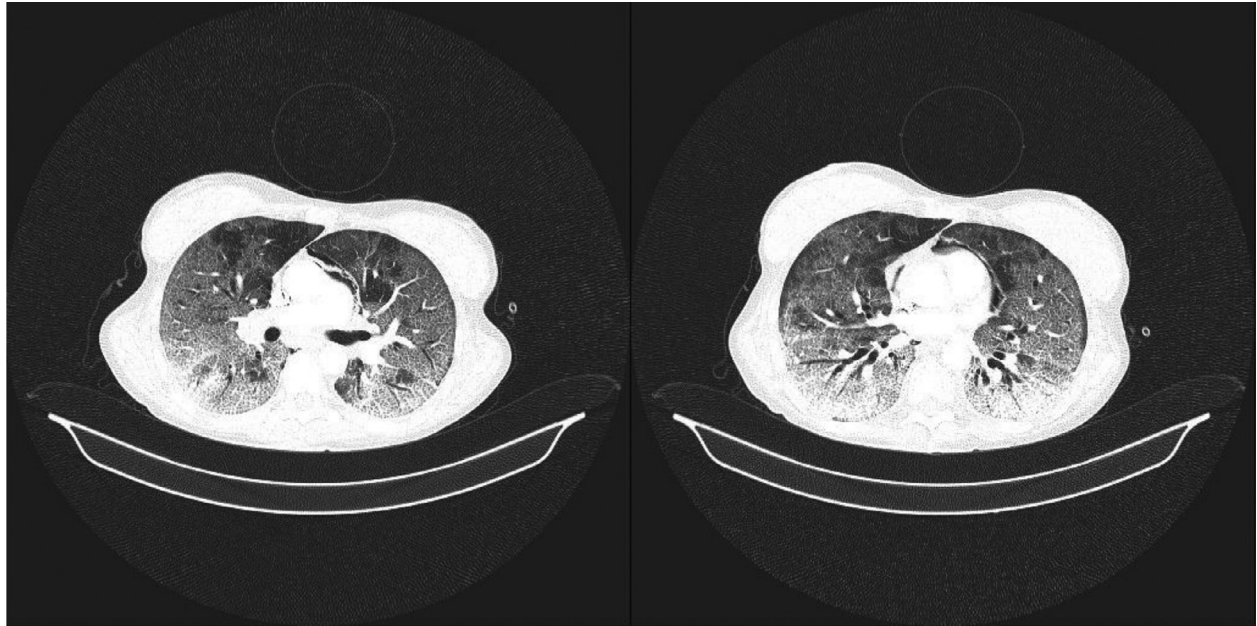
(Patient 1): Chest CT showing diffuse ground-glass opacities with interlobular and intralobular septal thickening producing a crazy-paving appearance characteristic of typical COVID-19 pneumonia. Low-to-medium abundant pneumomediastinum.
